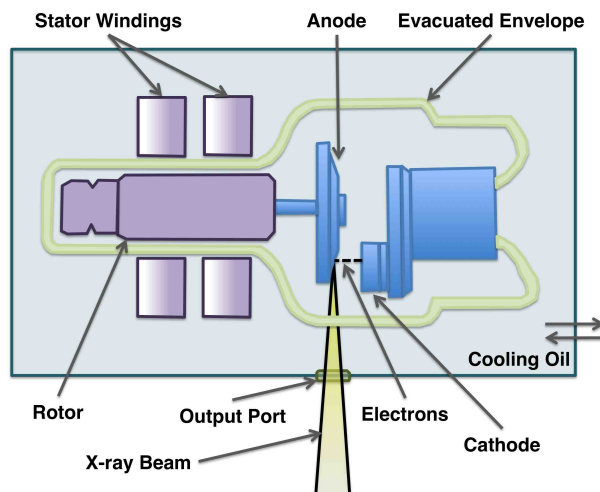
A typical x-ray tube consisting of an anode situated opposite a cathode in an evacuated metal envelope. Electrons boiled off the cathode accelerate across the envelope and strike the anode to produce kilovoltage x-rays [45].
